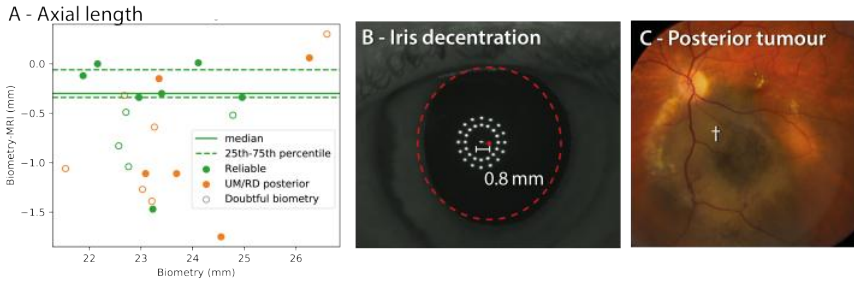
(A) Difference between MRI-based and biometry-based eye length measurements. For all patients including doubtful biometry (open dots) and patients with a UM or retinal detachment (RD) in the posterior pole (orange dots) on average 0.6 mm shorter measurements were found. For the remaining patients (filled green dots), there was generally a good agreement between both techniques, except for one patient where part of the sclera was included in the MRI measurement. (B,C) Two examples of doubtful biometry measures: (B) a large iris decentration is a sign the measurement was not obtained along the optical axis. (C) As the UM is covering the macula, the biometer reports a too short axial length.
